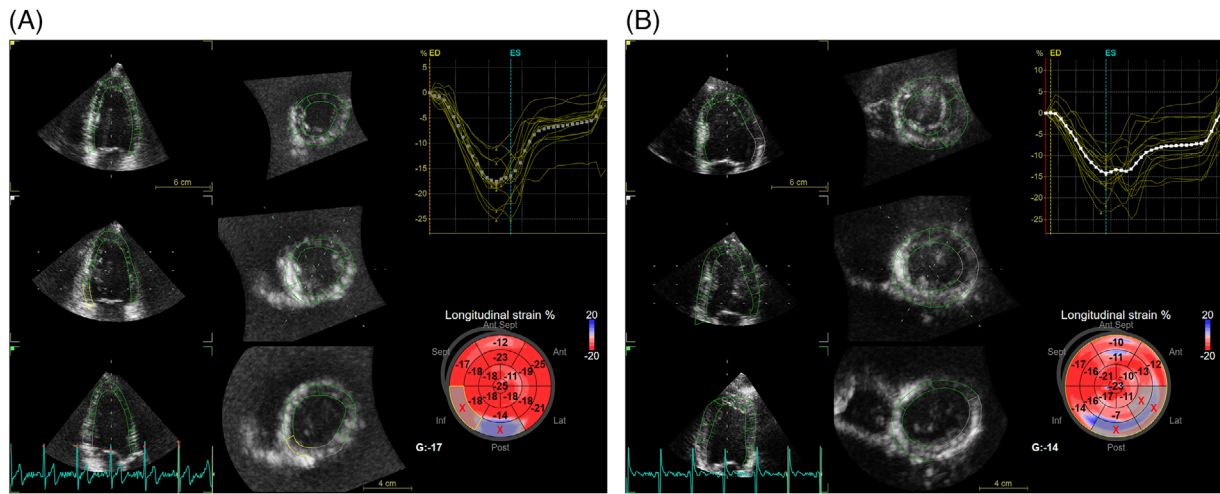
3D views of the LV. Example of 3D echocardiographic image in patients with mild (A) and severe (B) AS with corresponding LS curves and bull's-eye plot.
